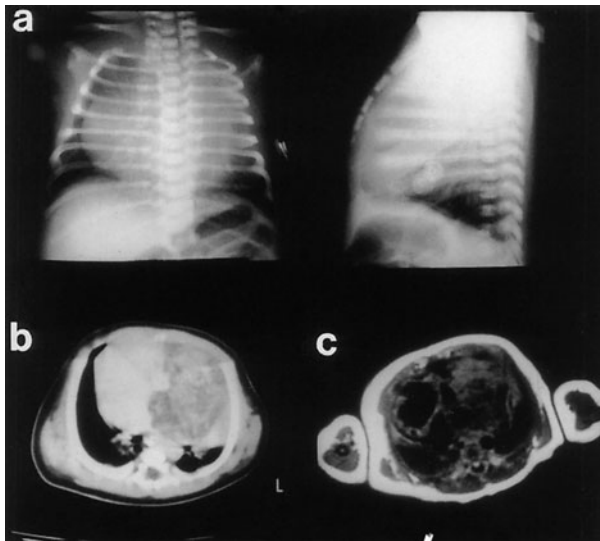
Cardiac teratoma with anterior mediastinal mass: (a) posteroanterior-lateral chest x-ray; (b) CT scan; (c) MRI.
